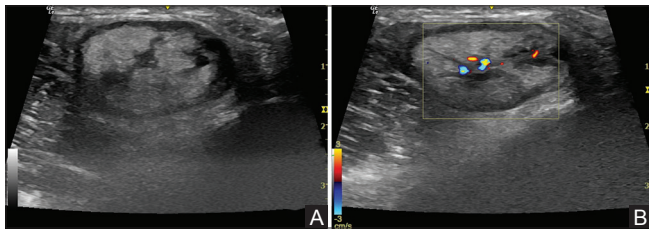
(A and B): Ultrasound showing well defined hyperechoic oval lesion with peripheral and central hypoechoogenicity (A). On color Doppler, the lesion shows central vascularity (B)
